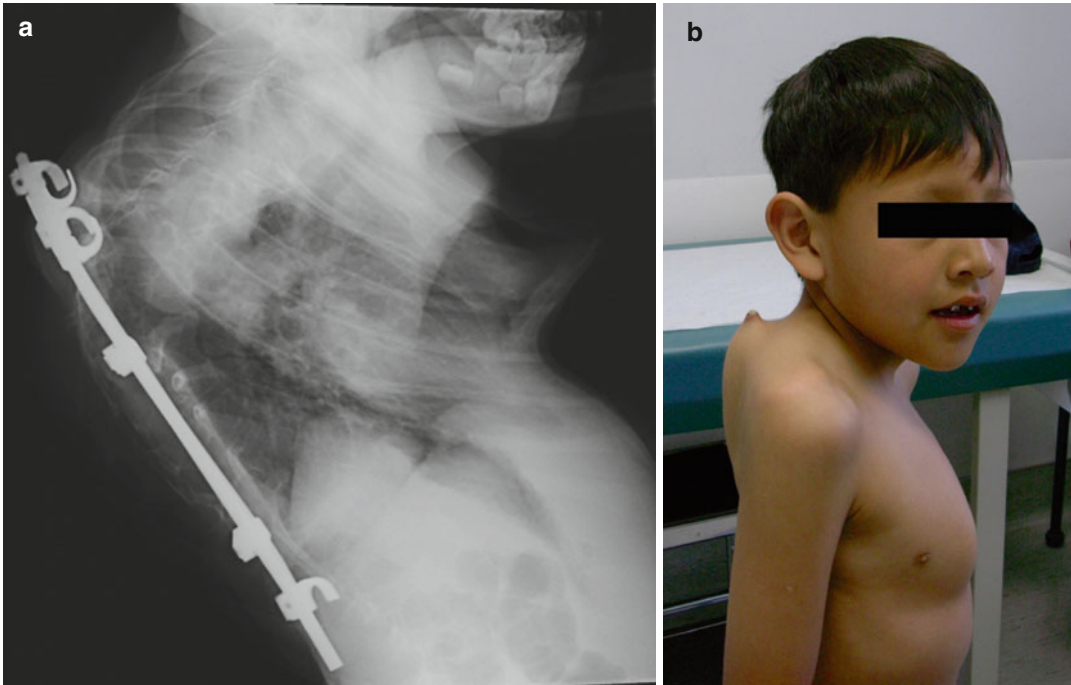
(a) Lateral radiograph demonstrating progressive kyphosis despite rib implants. (b) Clinical photograph demonstrating rod coming through the patient's
